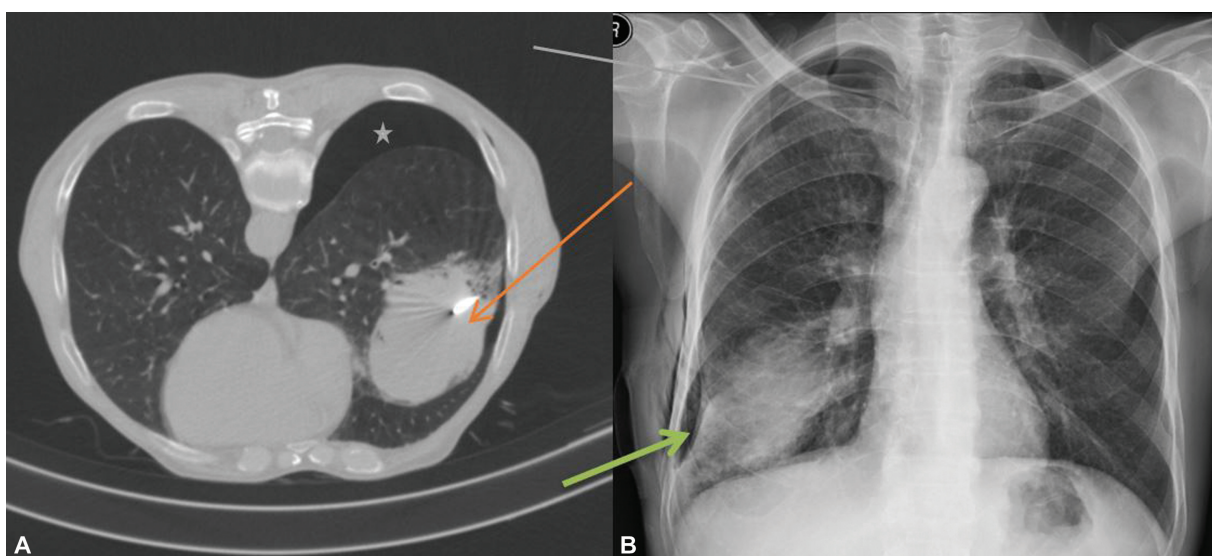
(A) Right lung mass lesion was approached in the prone position with coaxial needle in situ (red arrow), mild pneumothorax (green asterisk) in the CT scan. Note is made of a small focus of air near the chest wall beneath the muscular layer. (B) Mild subcutaneous emphysema at the local site and mild pneumothorax in the apical region in the chest X-ray (green arrow).
